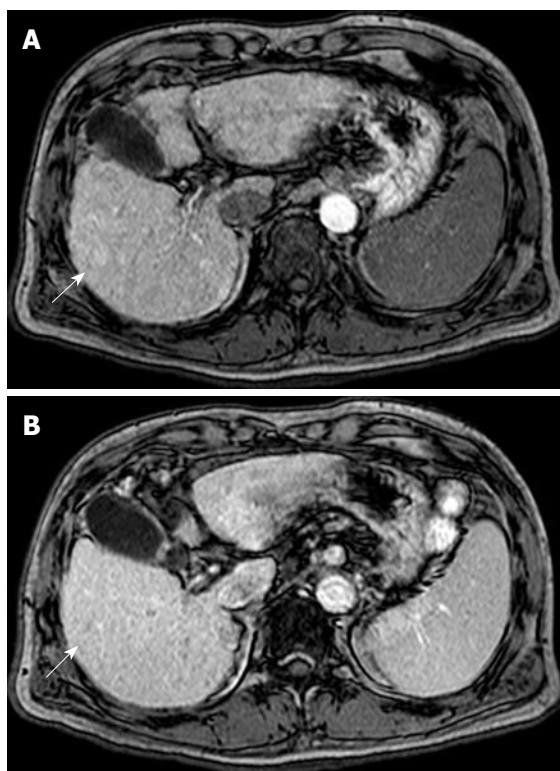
Contrast-enhanced MRI. A heterogeneous hypervascular nodule in the early phase (A) (arrow), and washout in the late phase (B) (arrow).
